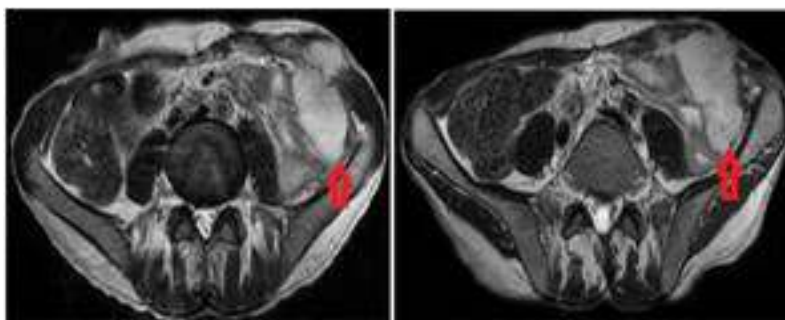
MRI images of the recurrent mass
